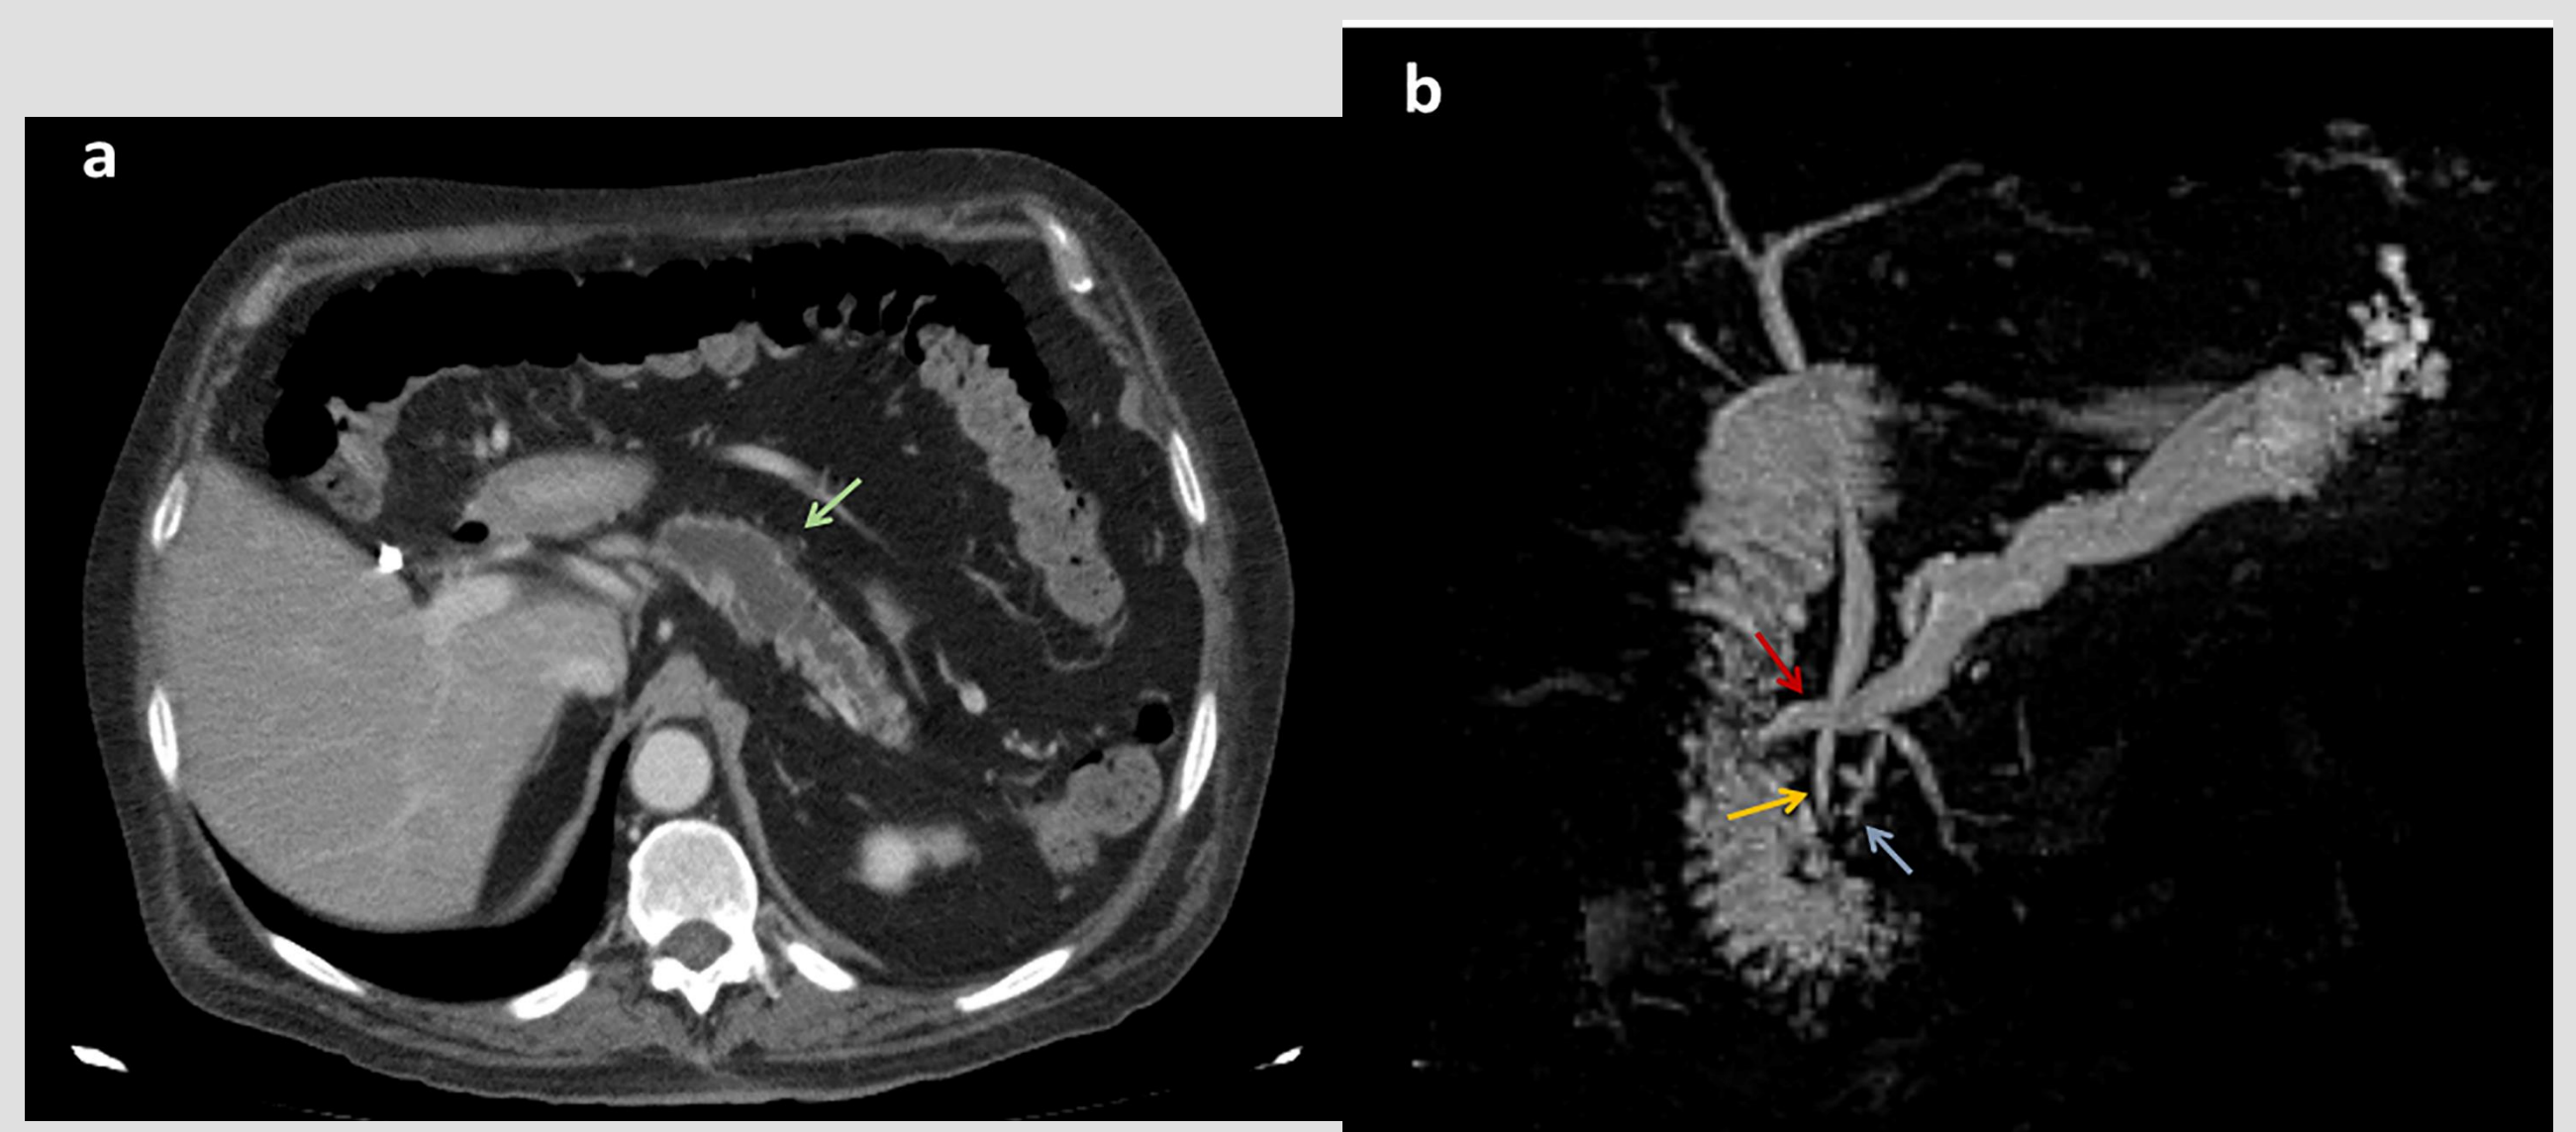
Enhanced CT scan images in axial view (a) showing diffuse dilatation of the main pancreatic duct in the pancreatic body and tail (maximum diameter of 22 mm in pancreatic body), with atrophy of pancreatic parenchyma without any pancreatic mass. MRCP 3D images (b) showing incomplete PD in which the dorsal pancreatic duct (red arrow) enters directly in the minor papilla and the ventral pancreatic duct (blue arrow) and main biliary duct (yellow arrow) enter the major papilla. There is also a filamentous connection between dorsal and ventral ducts. Note the diffusely dilated dorsal pancreatic duct.
